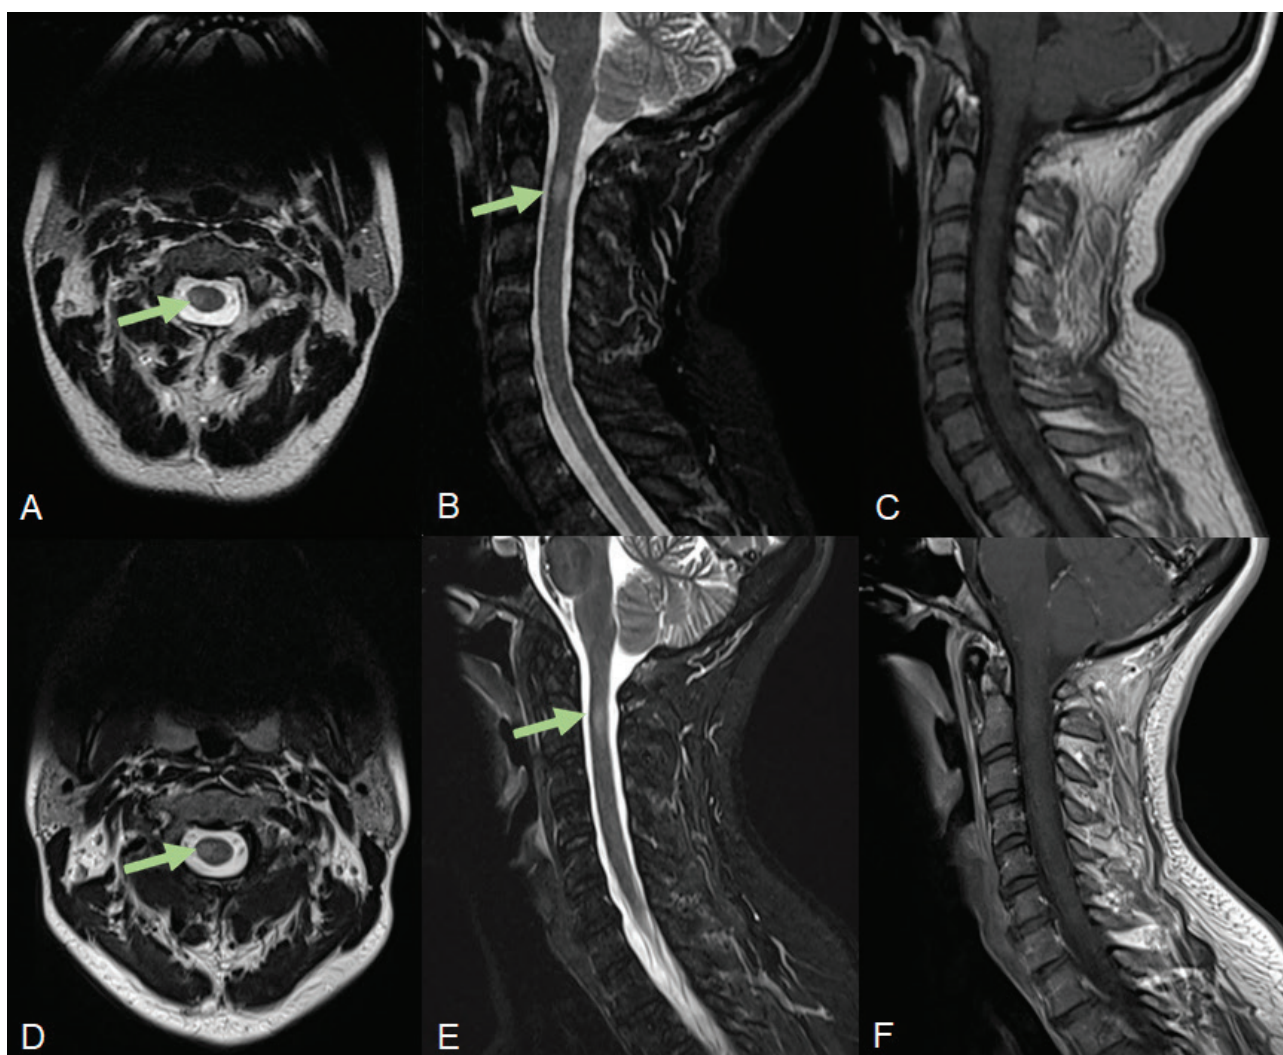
(A), (B), (C) – Neuroaxis MRI at 15-week follow-up; (D), (E), (F) – Neuroaxis MRI at 31-week follow-up; (A), (D) – axial and (B), (E) – sagittal T2-weighted showing progressive resolution of the previously described lesion. (C), (F) – Sagittal T1-weighted sequence with gadolinium, at 15- and 31-weeks MRI follow-up, respectively, without gadolinium enhancement.
